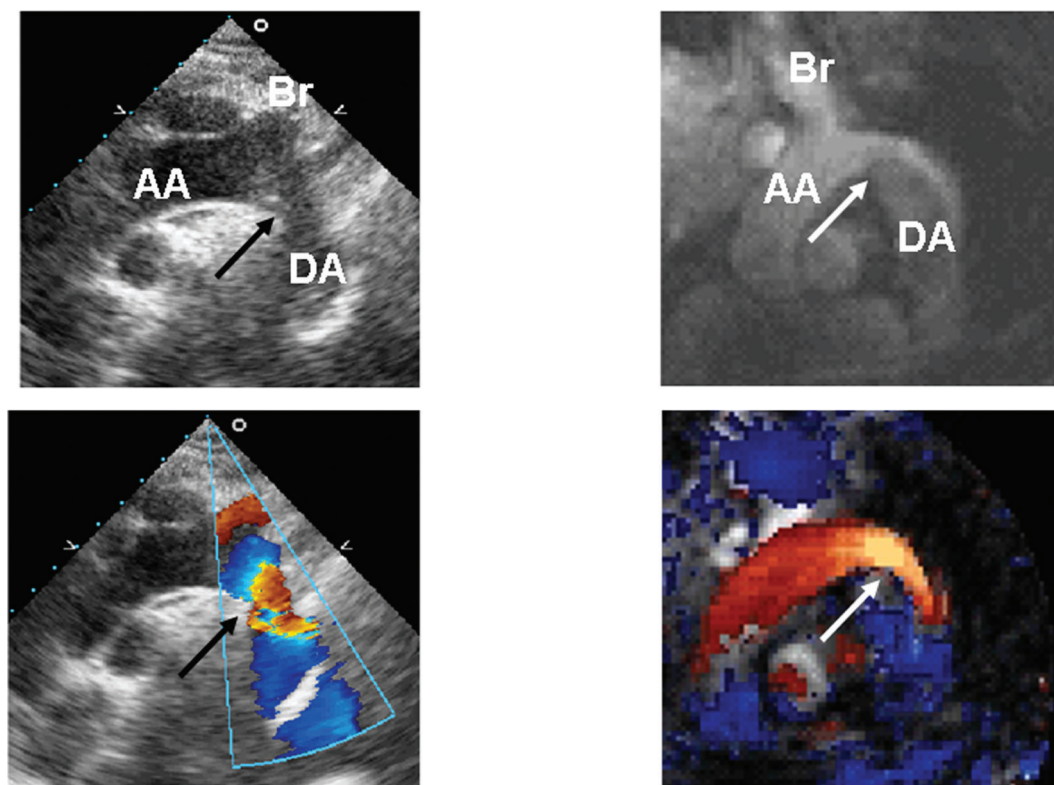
Aortic coarctation. Suprasternal ultrasound imaging (left images) shows the aortic arch (AA) with a mild residual coarctation (arrow) and flow acceleration by color-flow Doppler. Corresponding CMR (right images), with real-time color-flow CMR showing similar velocity acceleration at the site of coarctation (arrow). DA-descending aorta. Br-brachiocephalic artery. Supplemental material is available for this figure. Go to the publisher's online edition of *JCMR* for the images as movie clips.
